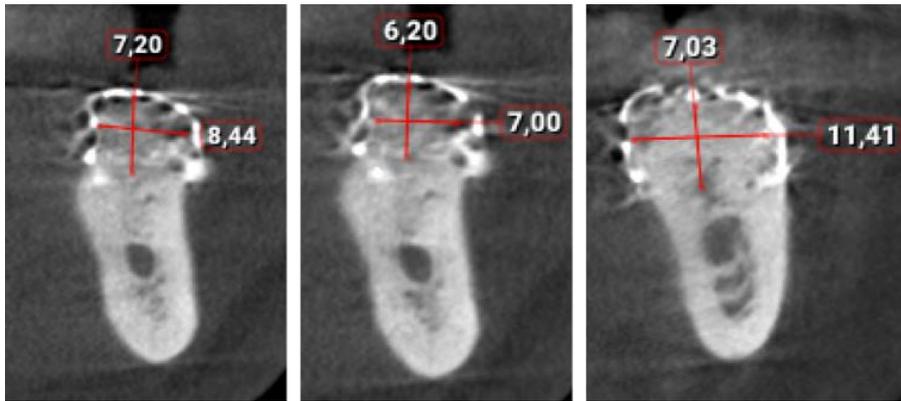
CBCT scans showing the vertical and horizontal bone gain in mm
